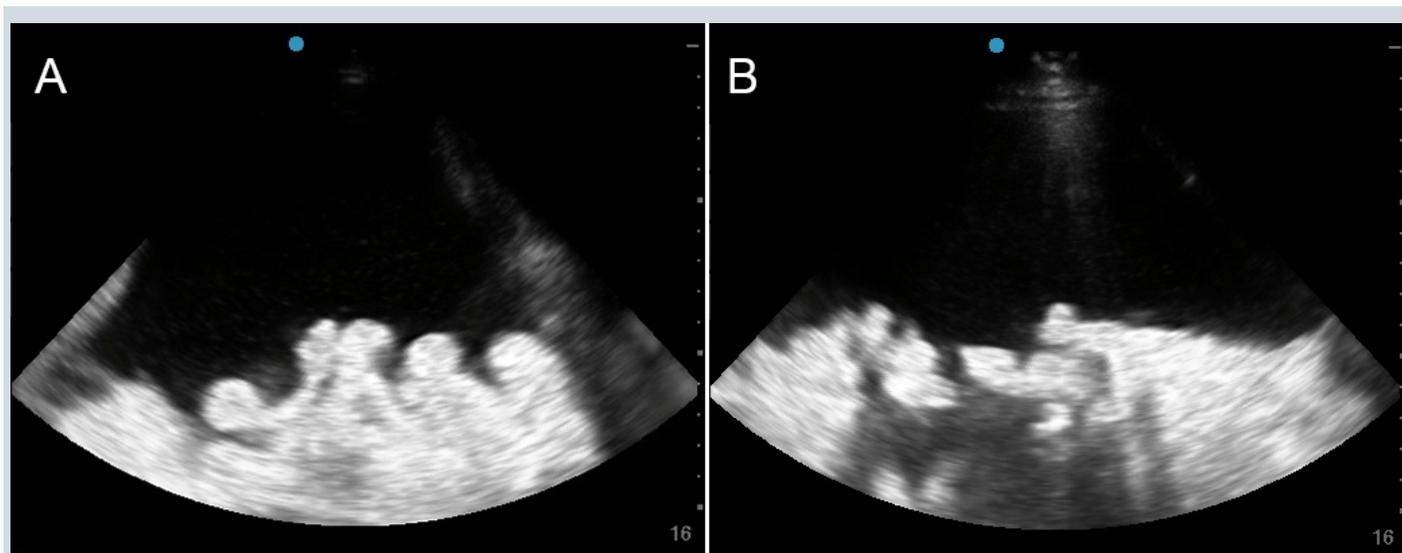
Representative examples of ascites prior to paracentesis as seen on point-of-care abdominal ultrasound.
